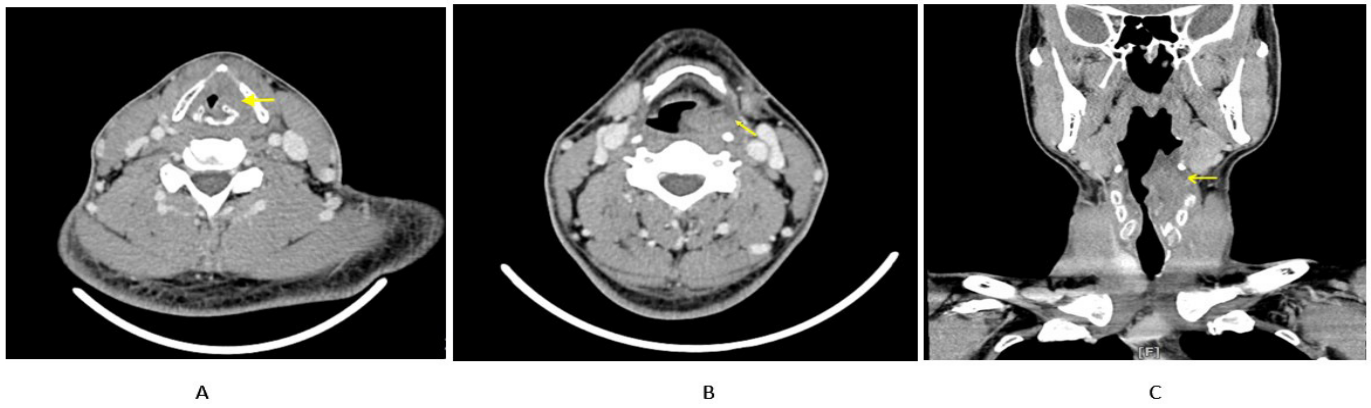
(a) Axial contrast-enhanced CT neck shows a 2.4 x 2 x 4.1-cm slightly high density lesion favored to represent hematoma or edema (arrow) close to the left side of larynx involving the left true vocal cord at glottic level. (b) Axial contrast-enhanced CT neck shows a 2.4 x 2 x 4.1-cm slightly high density lesion favored to represent hematoma or edema (arrow) close to the left side of larynx at supraglottic level. (c) Coronal contrast-enhanced CT neck shows a 2.4 x 2 x 4.1-cm slightly high-density lesion consistent with hematoma (arrow) close to the left side of larynx at about C4 to C5 levels involving the left supraglottic, glottic, and subglottic tissues.
